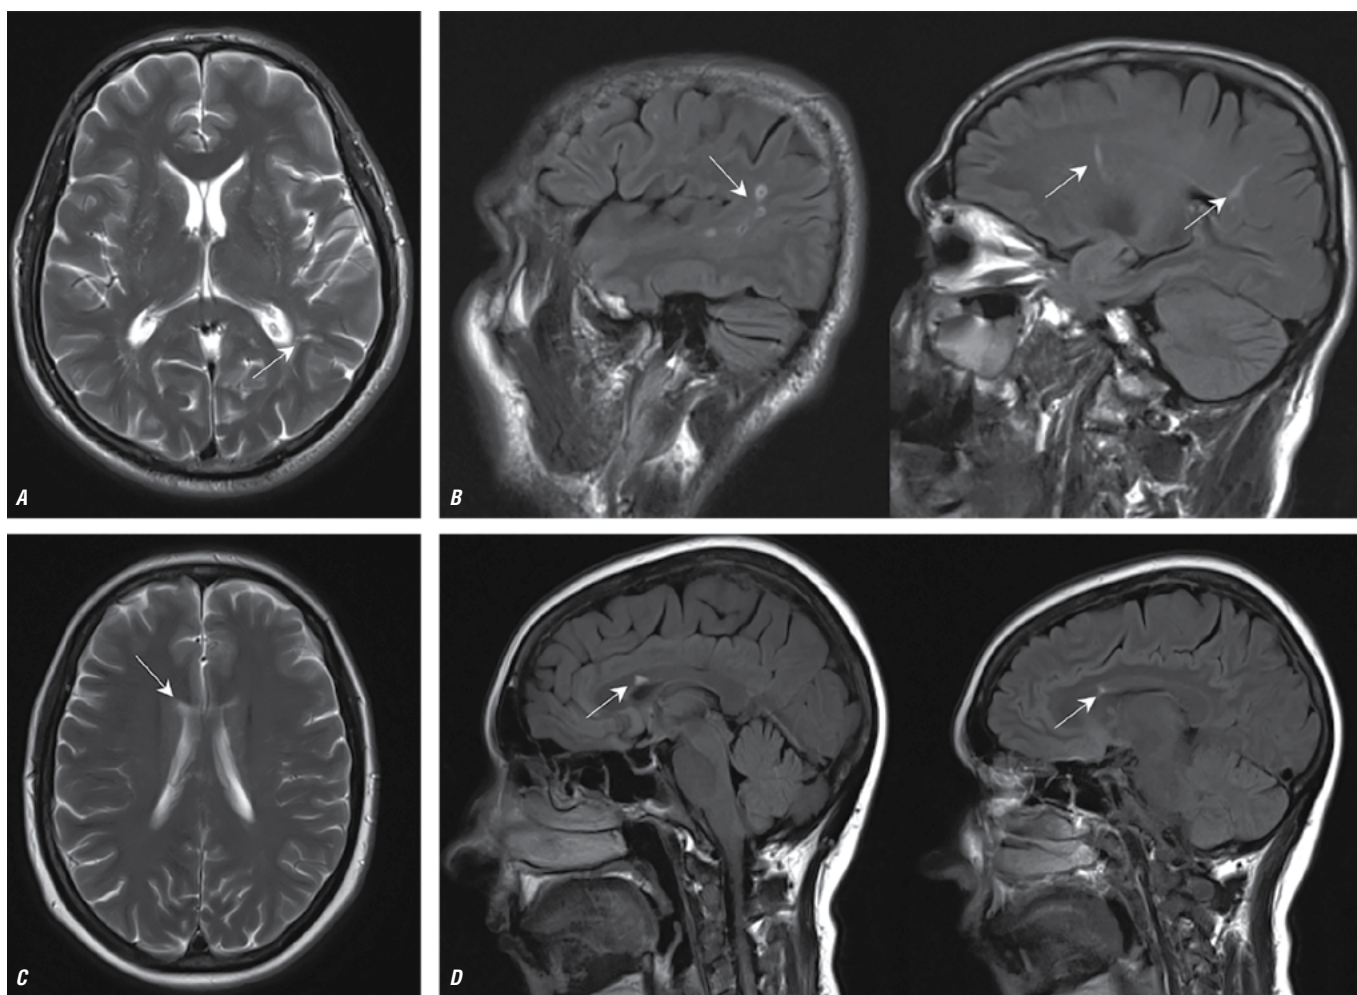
Brain MRI of patients with PMF in axial T2 images (A, C) and in sagittal T2 FLAIR images (B, D). Small post-infarction periventricular lesions are visualized (as indicated by arrows).
